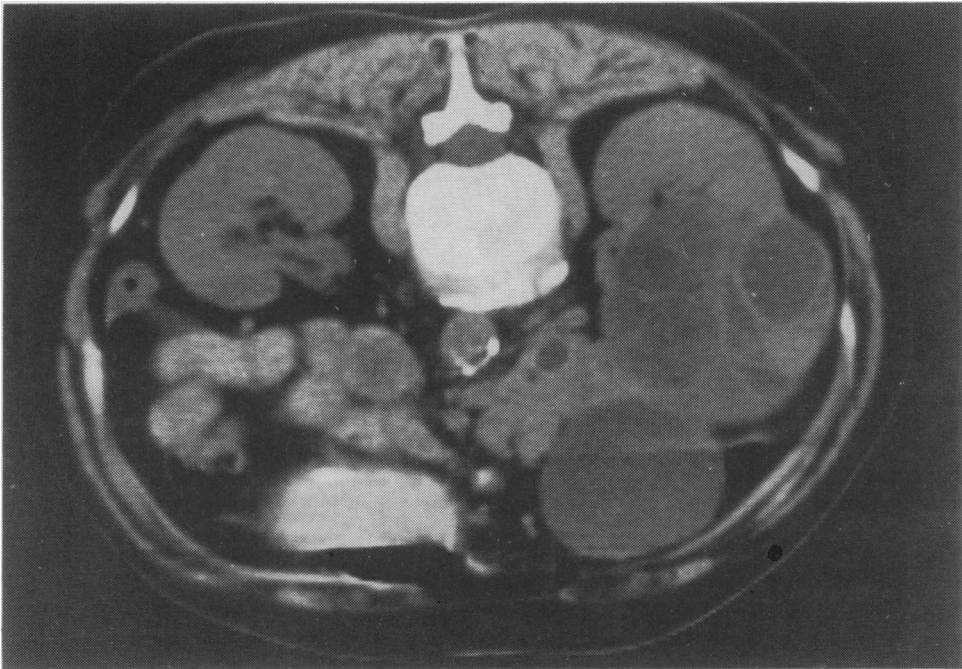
CT scan showing a large cystic lesion attached to the right kidney and suggesting invasion of neighbouring structures.
